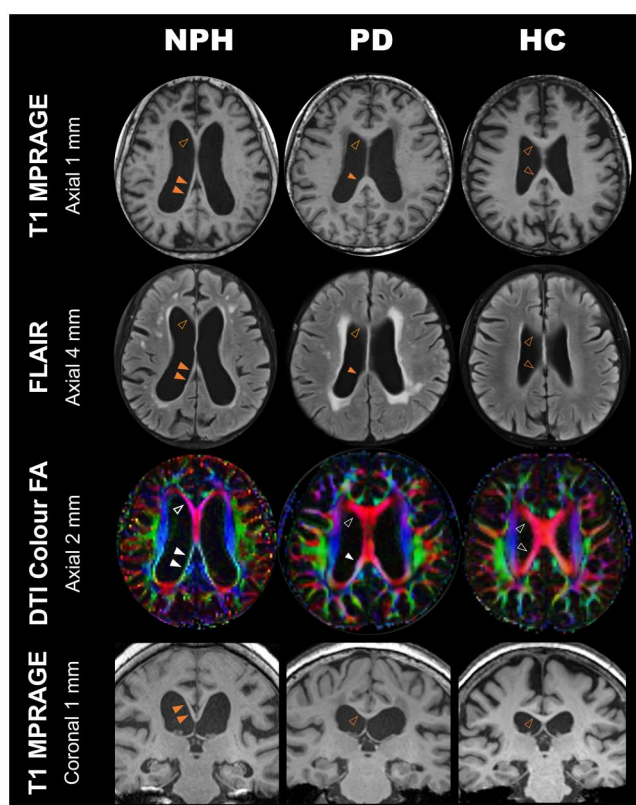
Greater vulnerability of the commissural fibres at the splenic/posterior end of the corpus callosum in idiopathic normal pressure hydrocephalus (NPH) depicted on T1 magnetization-prepared rapid gradient-echo (MPRAGE), fluid-attenuated inversion-recovery (FLAIR) and DTI colour fractional anisotropy (FA) images, and in contrast to Parkinson's disease (PD) and elderly healthy control (HC). More severe thinning and stretching of the splenic/posterior (double yellow arrowheads) corpus callosal fibres are seen against the ballooning ventriculomegaly compared to that anteriorly (open yellow arrowhead) in NPH (left column). This is most obvious on the DTI colour FA images (third row), where the normally red-encoded commissural fibres (see HC, right column) reveal significant discolouration (double white arrowheads) in the NPH.¹³ This indicates their superomedial angular displacement and compression by the high rising ventricular roofs (fourth row, coronal images) in contrast to their more horizontal orientation in the HC (right column) and PD (middle column). Note the narrower splenic angle in NPH (double arrowheads) subtended between the posteromedial ventricular walls, in comparison to that (single arrowheads) in PD and HC.
